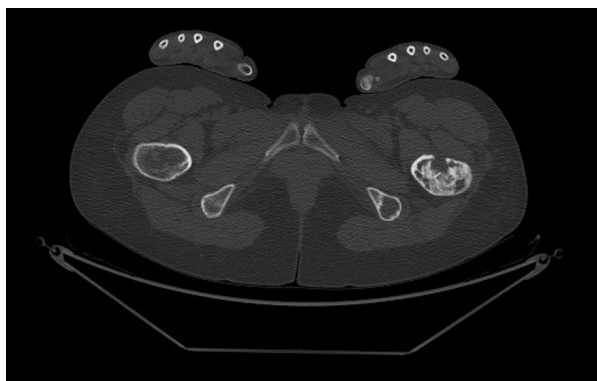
Infiltrative lesion in the left femoral shaft in computed tomography scan (patient 2)
